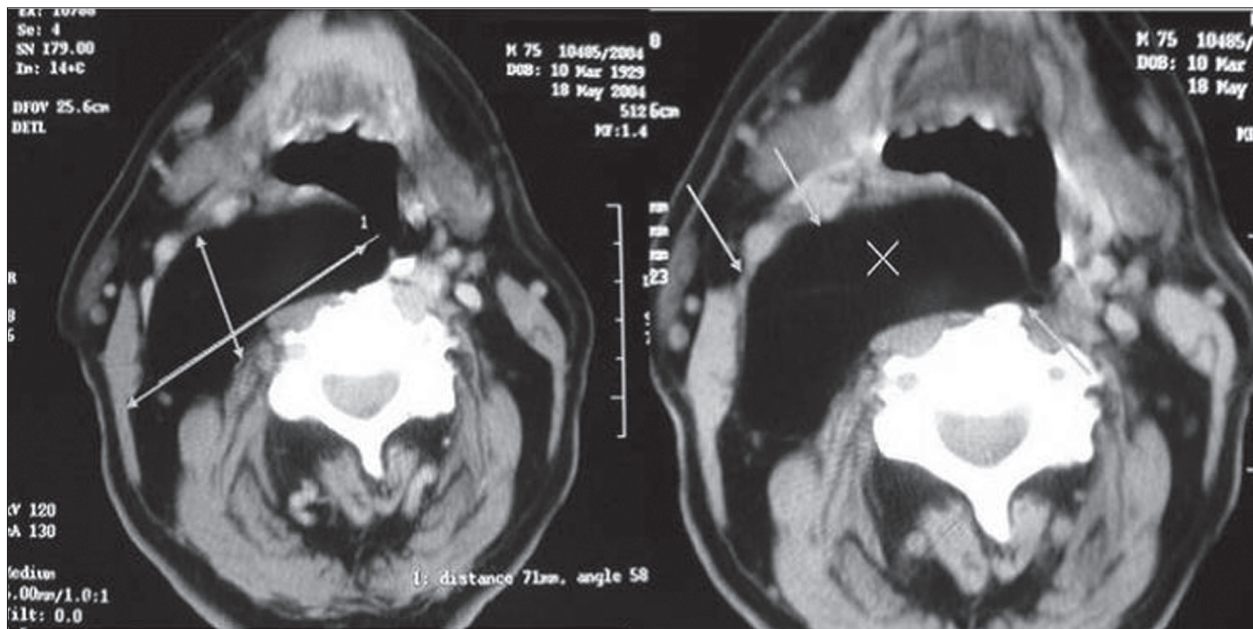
CT scans showing lipoma with total dimensions 85×58×72 mm
